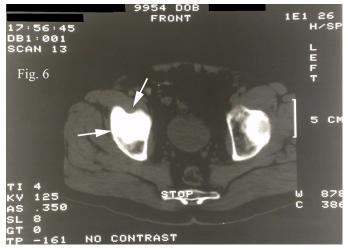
CT scan demonstrates mottled presentation.
